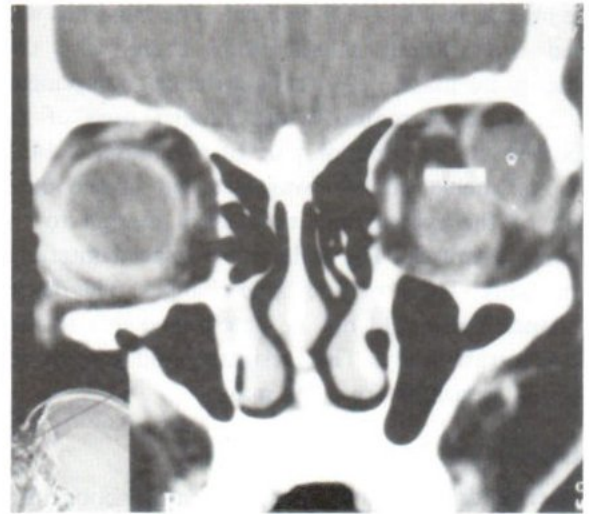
D Coronal view CT scan of the mass showed soft tissue content (25.5 H.U.)
